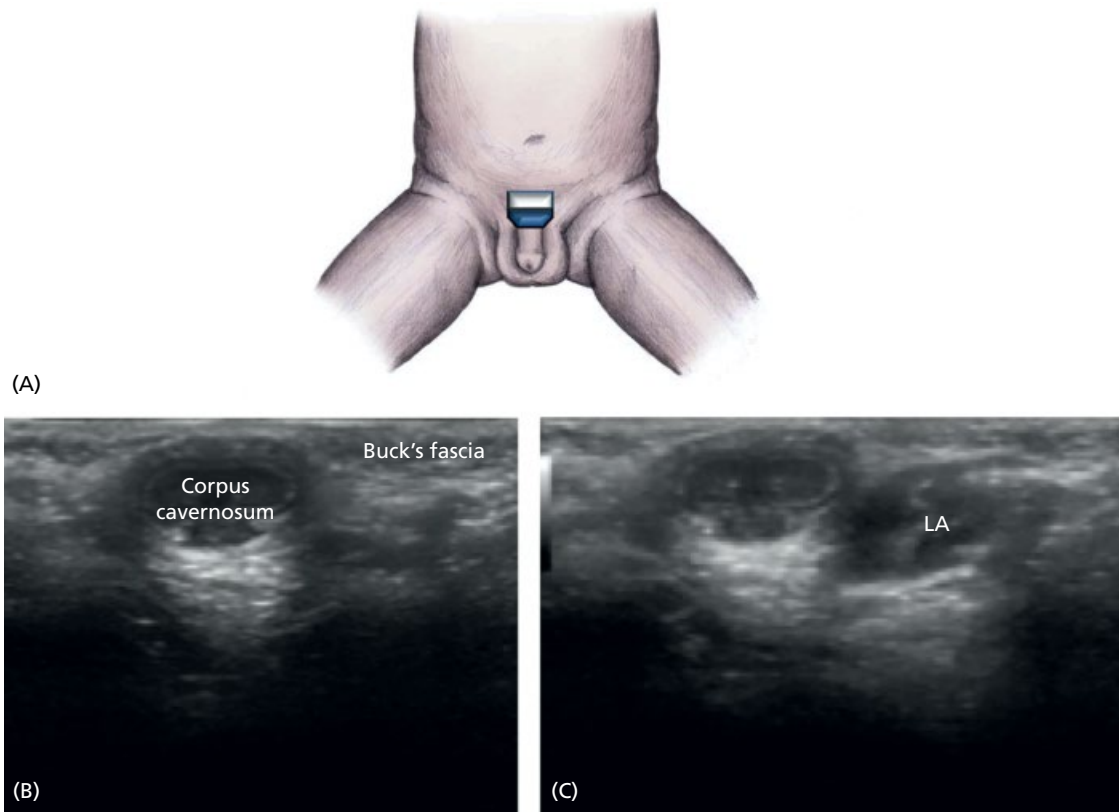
Ultrasound imaging of the penile block region. (A) Placement of linear or hockeystick ultrasound probe. (B) Puncture site without local anesthetic. (C) Subpubic space with local anesthetic (LA) in the correct place.
